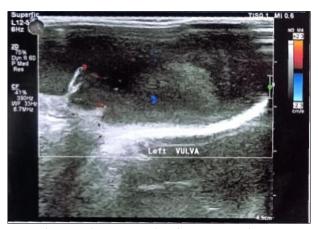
High Resolution Sonography image
